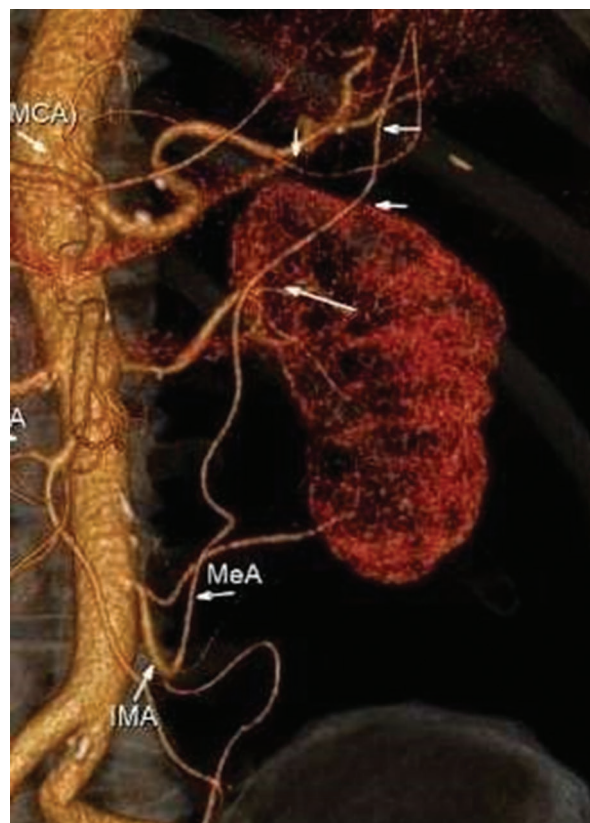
Three-dimensional-computed tomography angiography: Moskovich's artery marked by arrows (MeA). IMA: inferior mesenteric artery; MCA: middle colic artery.
